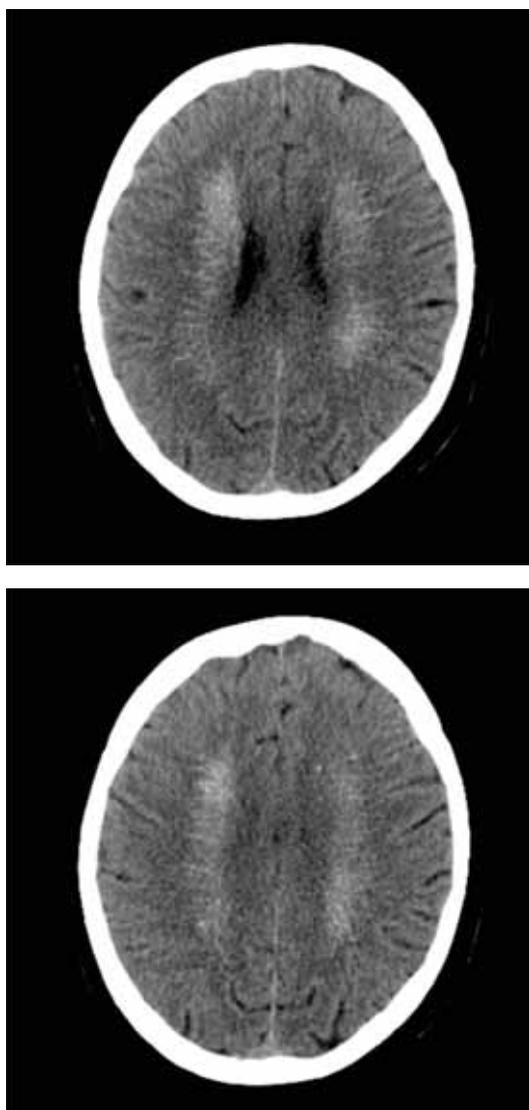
Computed tomography revealed radially disposed subcortical white matter calcifications
